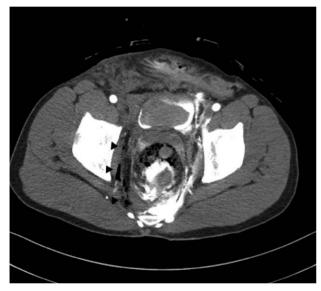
Multifocal air densities (black arrowhead) and hematomas around rectum were detected on abdomen CT scan. Perirectal contrast was infused through foley catheter at previous hospital.
